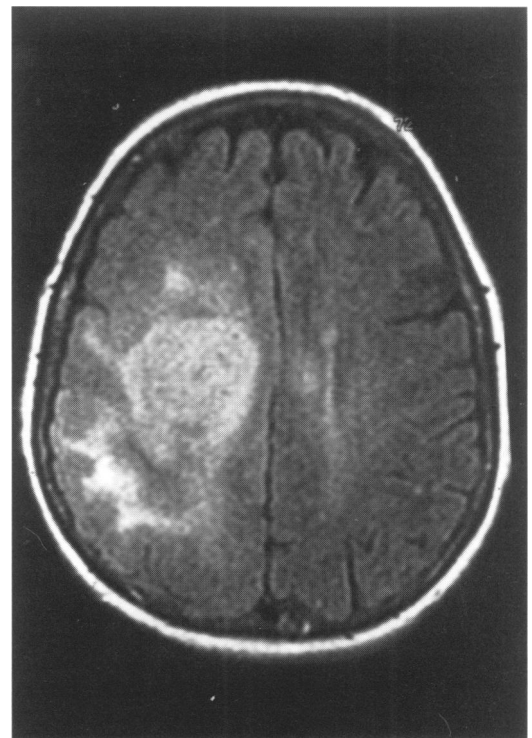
Repeat brain MRI
